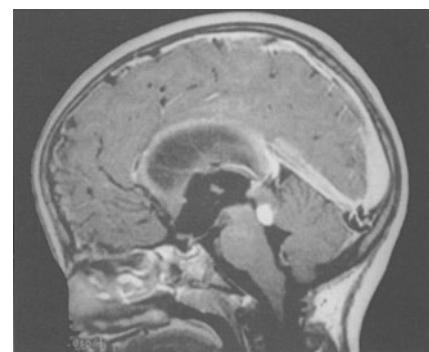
A 9-year-old girl with hydrocephalus. MRI shows a small astrocytoma infiltrating the tectum. A nodule is enhancing
